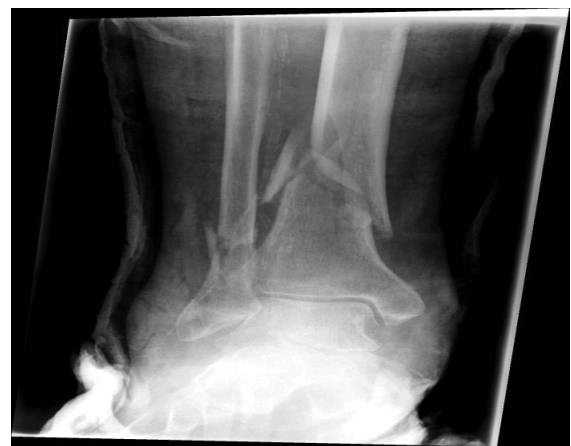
AP radiograph of distal tibia and fibula fracture.
